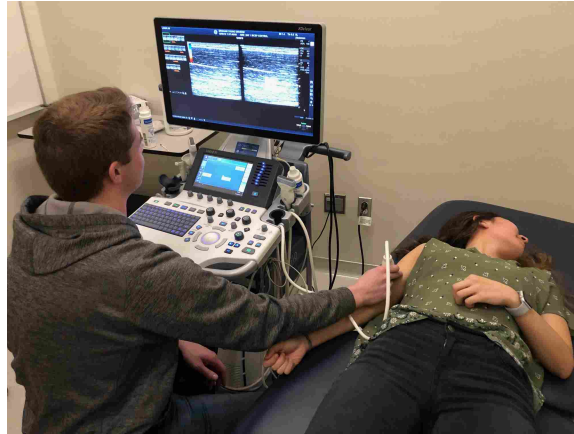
Ultrasound configuration used for gathering shear-wave elastography data from study participants.
